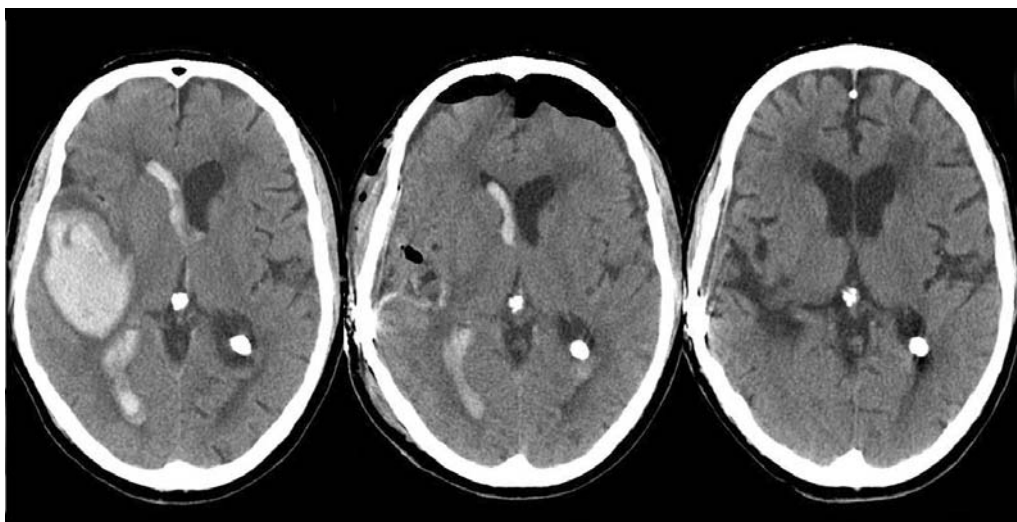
A 78-year-old man taking coumadin for atrial fibrillation presented with a right temporal-parietal intracerebral hemorrhage. Initial coagulation parameters were a PT of 28, INR of 2.8, and aPTT of 36. After a 90 $\mu\text{g}/\text{kg}$ dose of rFVIIa, the values immediately corrected to a PT of 9.6, INR of 0.9, and aPTT of 32.0. The patient then underwent an uncomplicated craniotomy for clot evacuation. (Left) Axial noncontrast CT obtained at presentation. (Middle) Axial CT obtained 1 day postoperatively. (Right) Follow-up CT obtained 6 weeks postoperatively.
